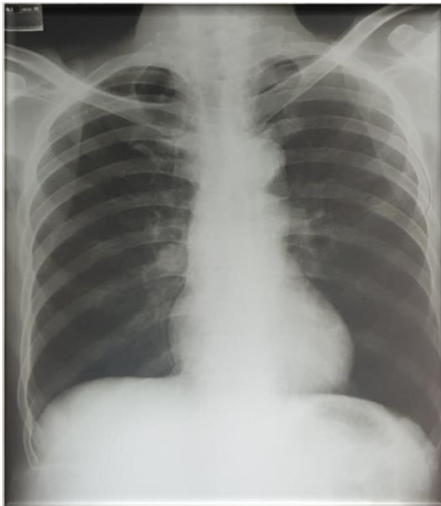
Chest radiograph of patient showing normal findings
